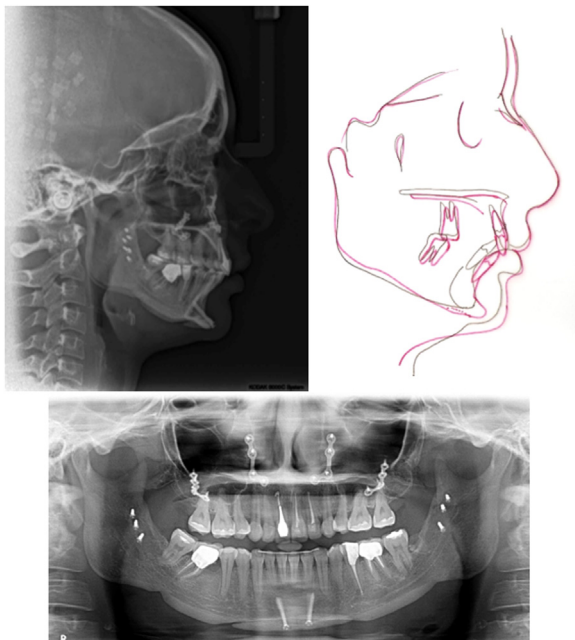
Patient 1. Posttreatment lateral cephalometric radiograph, tracing and panoramic radiograph.
